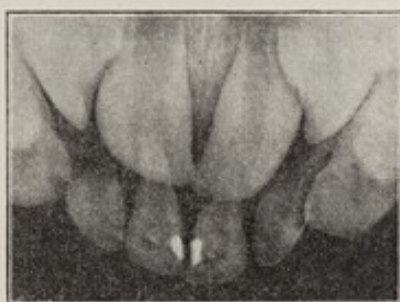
Radiograph of upper front teeth of boy seven years old. The right temporary central incisor was abscessed and resorption of the root had not occurred. The shadow of the root of this tooth may be seen overlapping that of the permanent central crown.
